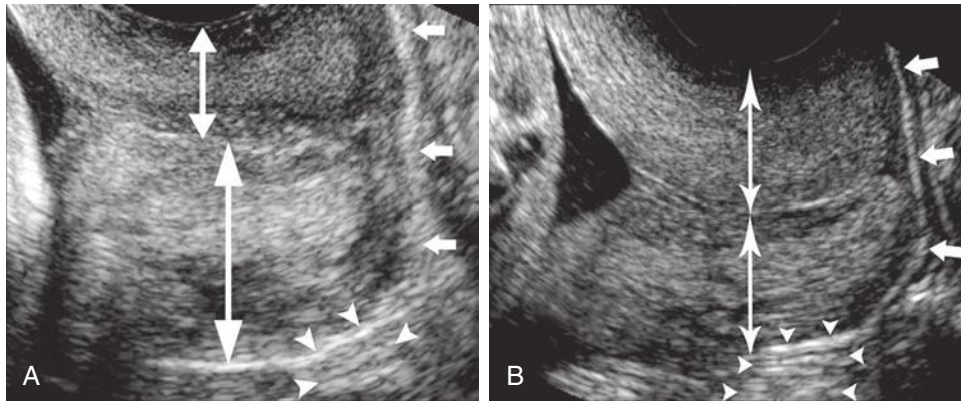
A, Ultrasound image of the cervix with excess manual pressure from the transvaginal probe. The anterior lip of the cervix appears significantly thinner than the posterior lip of the cervix (*double-headed arrows*). Small triangular markers (*arrowheads*) show increased echogenicity below the posterior lip of the cervix, an indication of excess pressure. B, The anterior and posterior portions of the cervix appear equal in thickness (*double-headed arrows*). The transvaginal transducer should be inserted just enough to adequately visualize and obtain a reliable measurement of cervical length, without altering anatomy. Vaginal mucosa appears hyperechoic (*small short arrows*).
